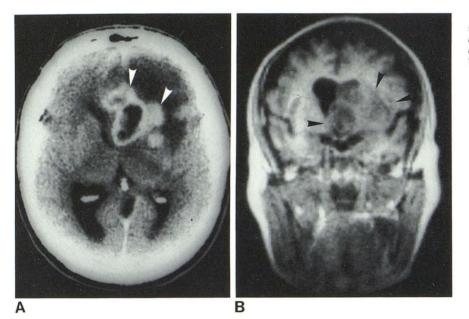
Malignant glioma, 55-year-old man. A, CT scan. Contrast-enhanced frontal ganglionic mass (*ar-rowheads*). B, Coronal NMR scan. Mass (*arrowheads*) of decreased signal intensity involves deep frontal white matter and basal ganglionic structures.
